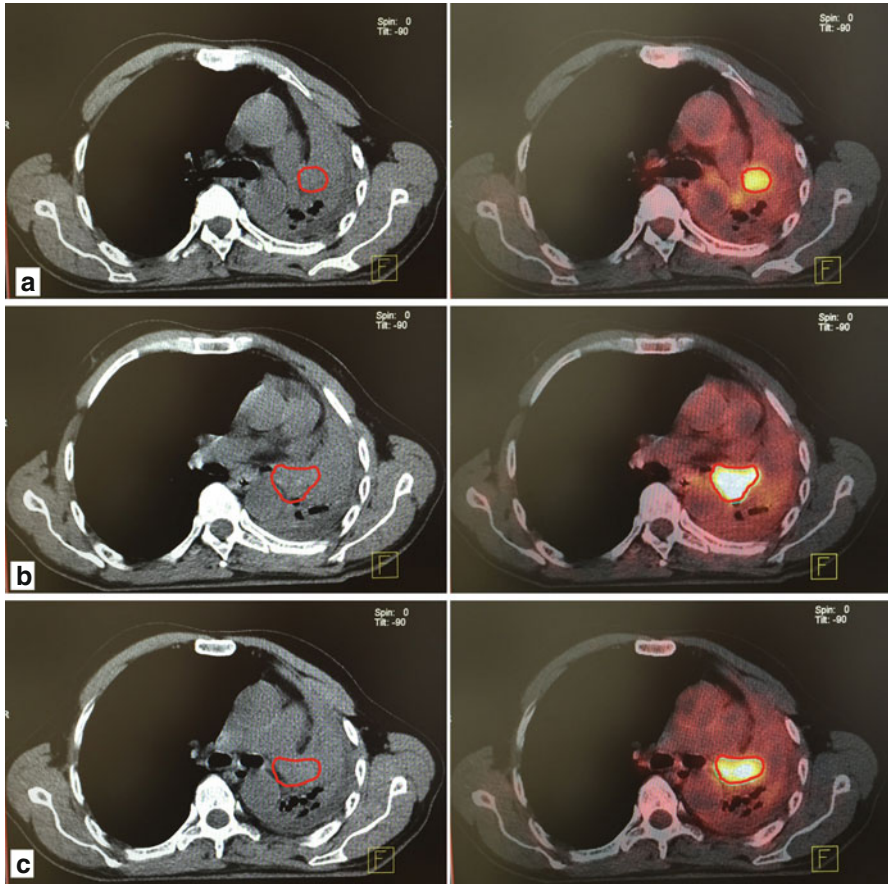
The planning computed tomography (CT) images of a 62-year-old male with T4N2M0 squamous cell lung carcinoma. (a) Show the superior, (b) show the middle, and (c) show the inferior parts of the primary tumor. Prominent atelectasis is observed in the left lower lobe around the primary lung lesion. (a–c) Images on planning CT and the corresponding fusion images of planning CT and positron emission tomography (PET)/CT). Although the distinction between the primary tumor and atelectasia cannot be made on the prior figures, the tumor can be clearly identified from the atelectatic regions on the latter figures
